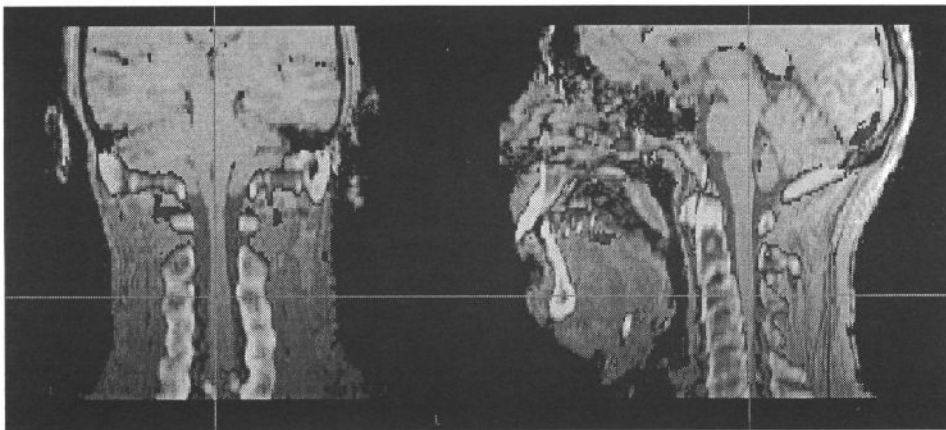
Rigid body image registration of an MR and CT image pair, white-CT, grey level-MR, showing two orthogonal slices through the neck. Left is the coronal or side-to-side slice and right is the sagittal or front-to-back slice. The cut planes are indicated by the cross hairs.
